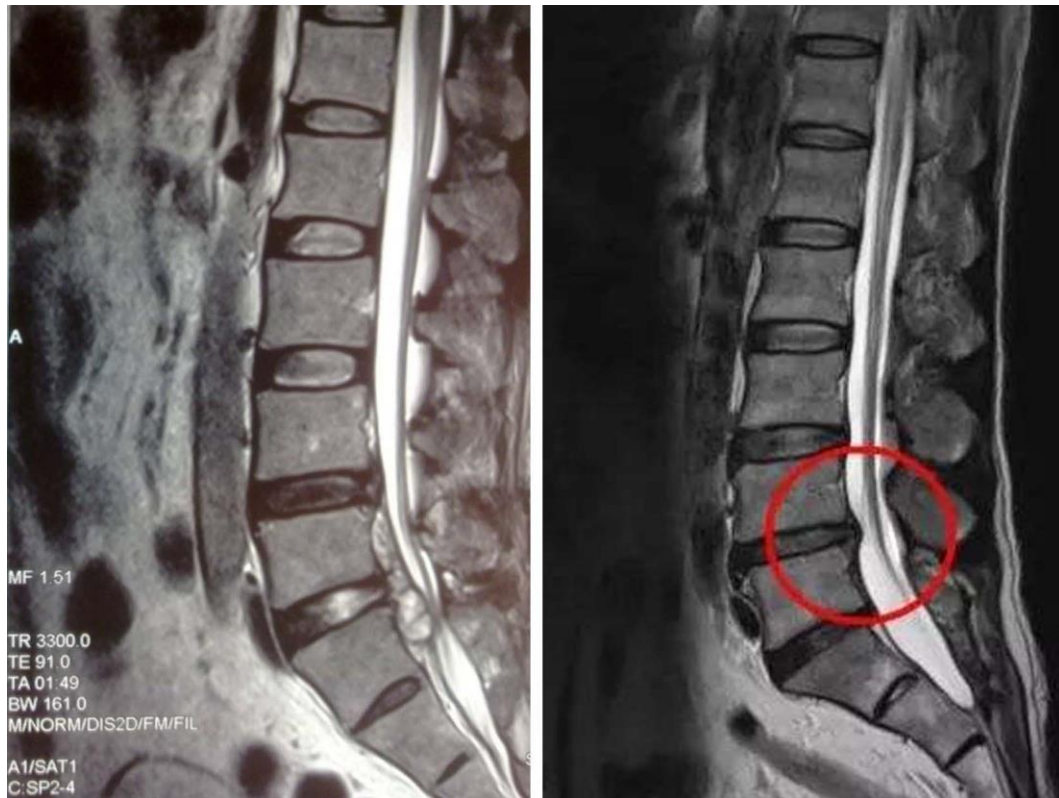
CT and low field MR imaging of fibrous ring, vertebral endplate and cartilage endplate integrity and integrity distribution after operation.
